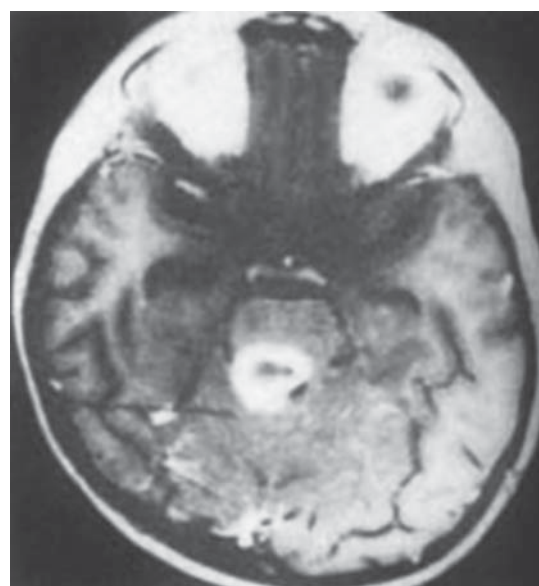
Magnetic resonance imaging demonstrating a tuberculoma. Note the ring like discrete lesion with considerable surrounding edema. Most often, pediatric tuberculoma is solitary and infratentorial, located at the base of the brain near the cerebellum.
